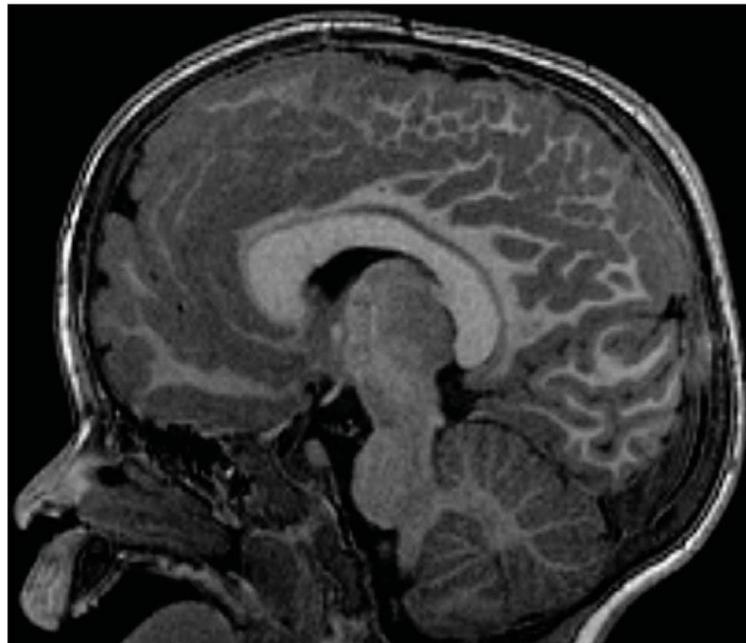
T1-weighted image on the sagittal plane that highlights a hyperplastic corpus callosum
